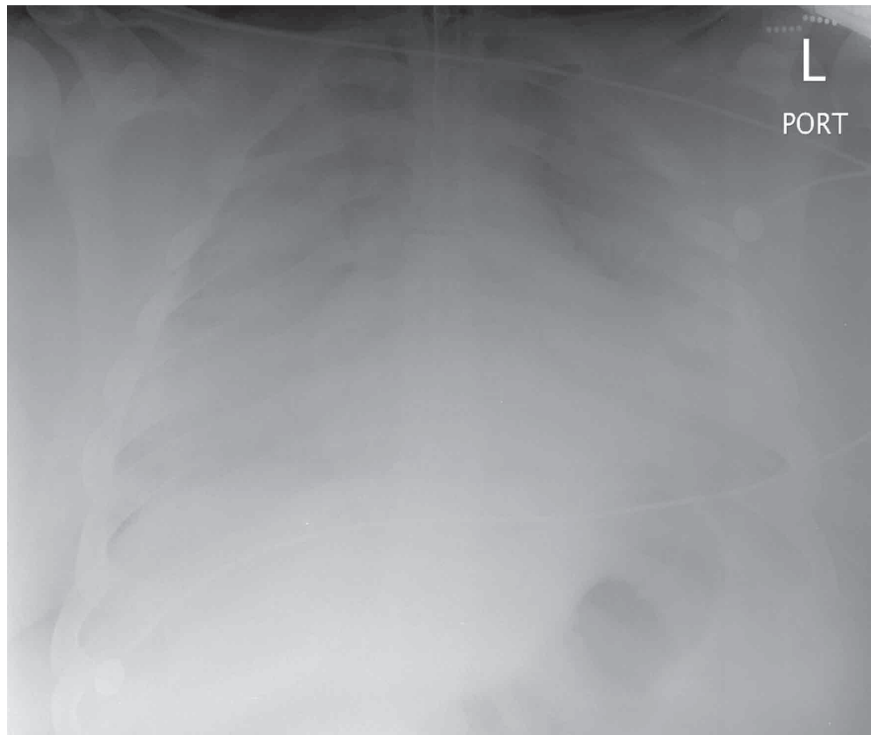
PORTABLE AP CHEST RADIOGRAPH ON DAY 2
